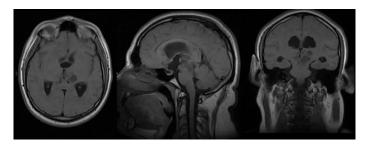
Brain magnetic resonance imaging axial, coronal, sagittal section in T2 sequence.
